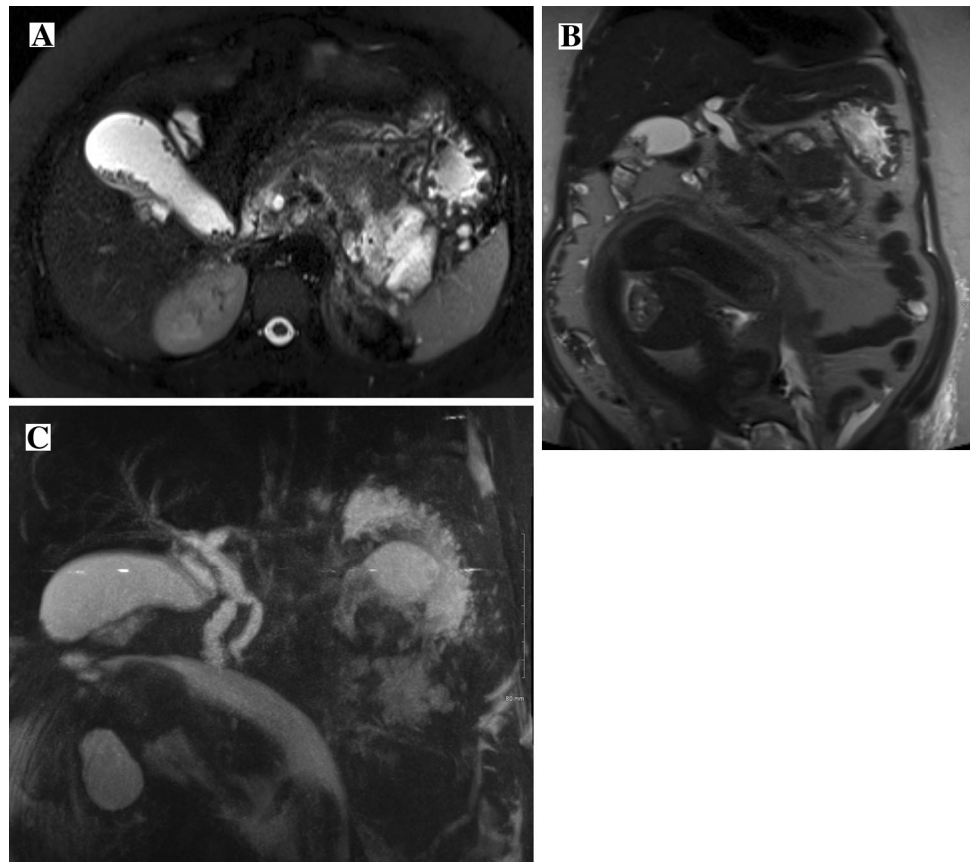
30-year-old pregnant woman with biliary pancreatitis. Axial (a) and coronal (b) T2-weighted, fat-suppressed single-shot fast-spin echo, as well as maximum intensity projection reconstruction from an MRCP (c), reveal an enlarged heterogeneous pancreas with moderate peripancreatic stranding surrounding the pancreatic body and tail, representing acute pancreatitis. There is also a large complex fluid collection surrounding the body and tail of the pancreas, with hemorrhagic and proteinaceous components, representing pancreatic and peripancreatic necrosis. Mild biliary ductal dilatation is also present, with narrowing of the common bile duct at the level of the ampulla. Gallbladder distension seen with numerous gallstones and cystic duct stones, and choledocholithiasis at the level of the ampulla. ERCP (not shown) performed 1 day later revealed common bile duct sludge and a calculus
